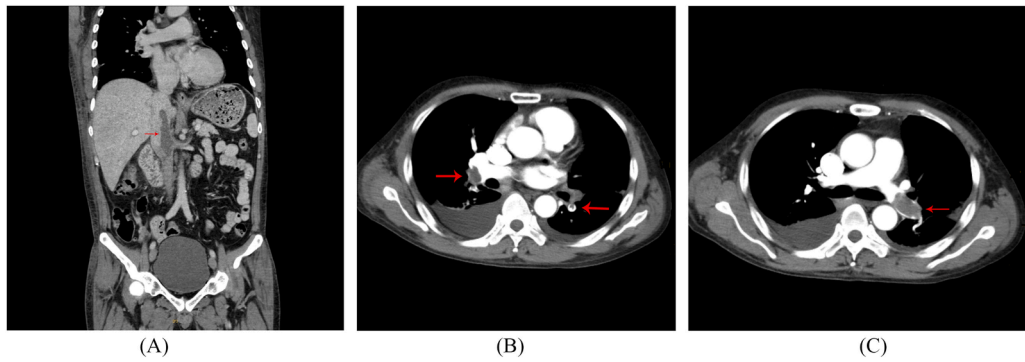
Computed tomography angiography of the chest and abdomen revealed thrombus at both right and left pulmonary arteries (B,C), and left renal vein thrombosis extending into the inferior vena cava(A).
